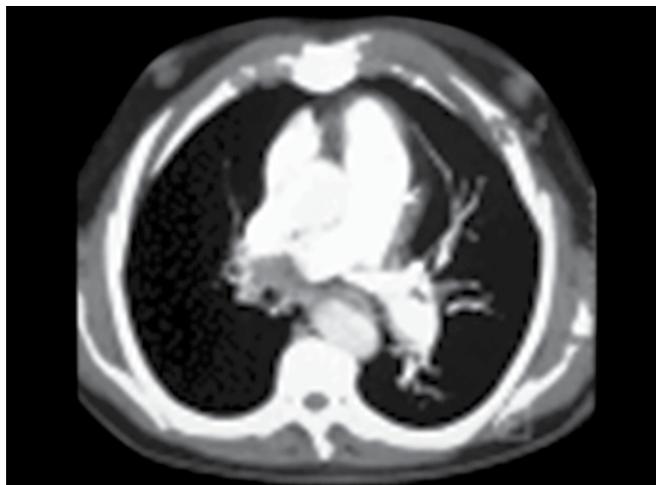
Lung CT scan with contrast angiography showing a filling defect in the RPA leading to complete obstruction
